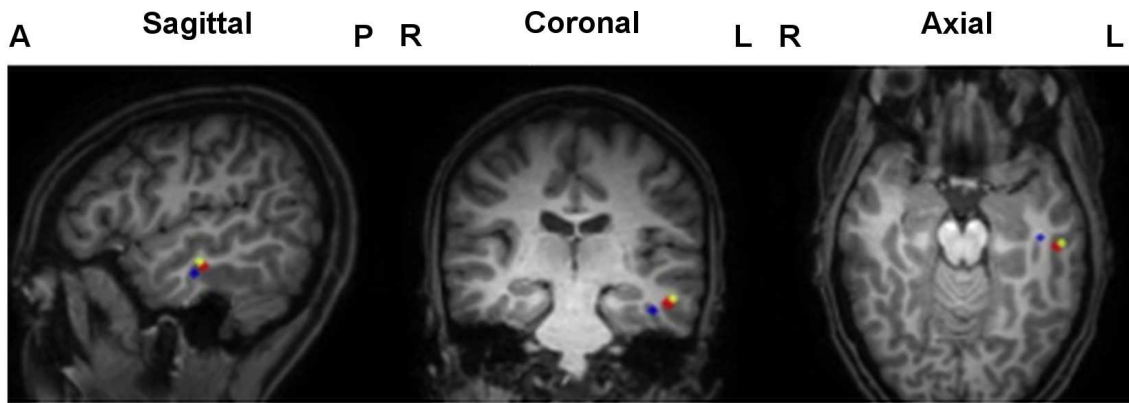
Best three DS locations in terms of metrics (cubes with color) for an exemplary MEG dipole scan for head model *6C_132* plotted on T1 MRI. The GOF values for these three locations are very close to each other (95.79 % (red), 95.76 % (blue) and 95.33 % (yellow)) but this small difference of (0.03 %) results in 9.8 mm difference (distance between the red and blue cubes) in the final dipole.
